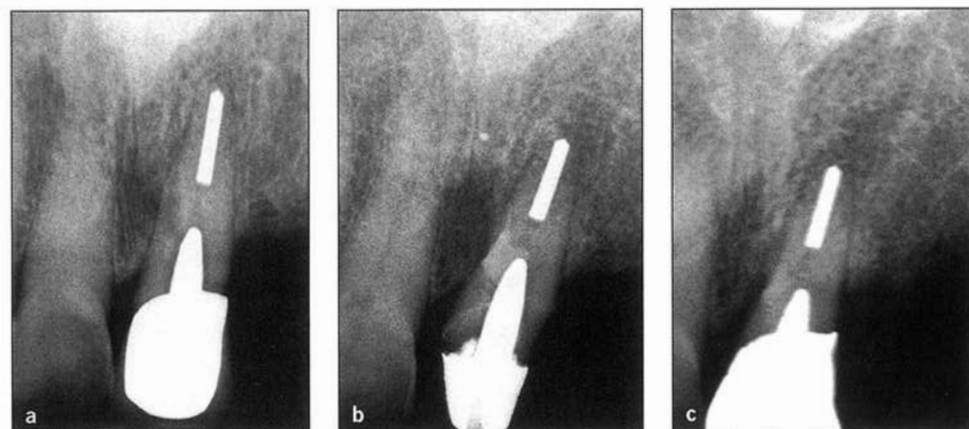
(a) Preoperative radiograph of a maxillary lateral incisor with coronal post perforation. (b) Postoperative radiograph after rotation of the tooth in its socket and repair of the mesiolingual perforation with MTA. (c) Postoperative radiograph 5 years after treatment showing complete healing. The tooth had no clinical symptoms and was an abutment for a partial denture.
